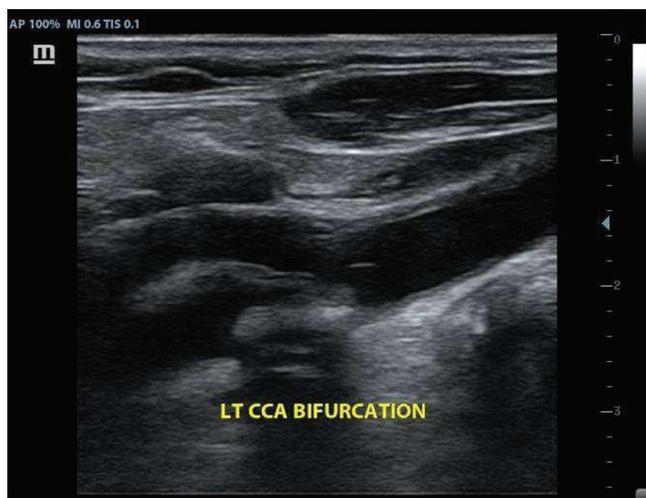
In same patient longitudinal grey scale ultrasound images of the left carotid artery shows echogenic plaque giving posterior acoustic shadowing noted in the left internal carotid artery and causing significant stenosis
